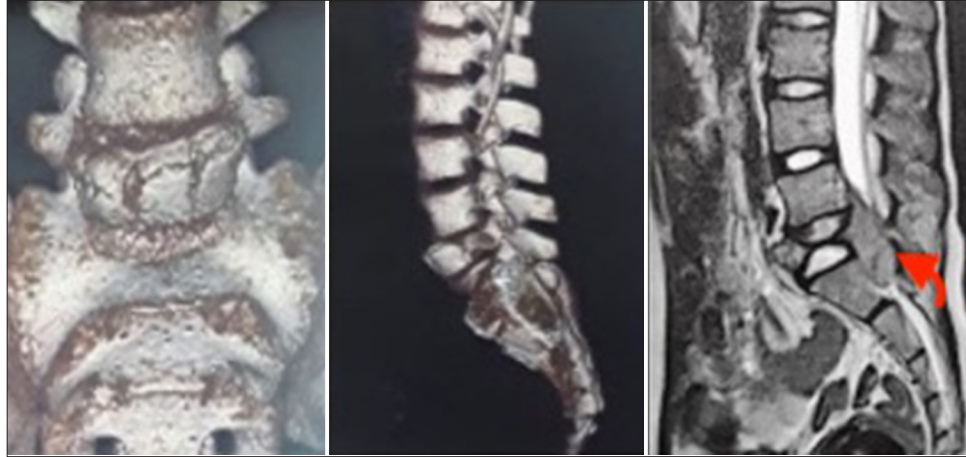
Magnetic resonance imaging and computed tomography showing the tumor-infiltrating the body and the posterior arch of L5 with extension into the spinal canal (Red arrow: The extension).
